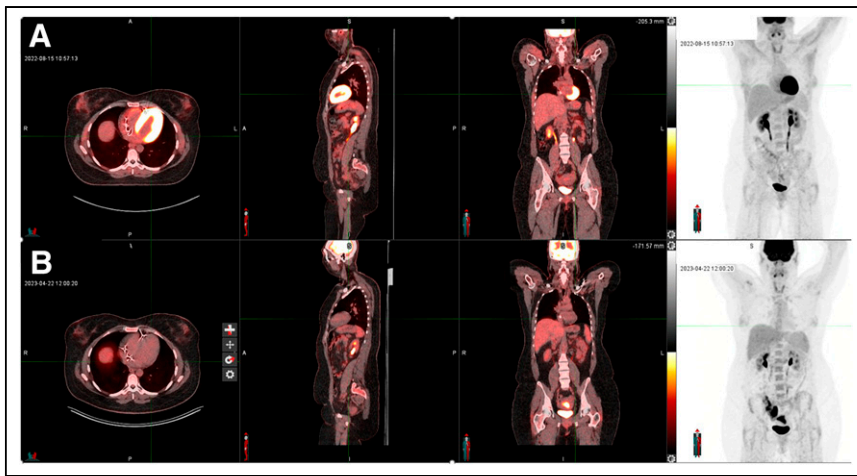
^{18}F -FDG PET/CT images in transaxial, sagittal, and coronal planes and maximum-intensity projection images. (A) Intense ^{18}F -FDG uptake in LV myocardium due to inadequate preparation. (B) No uptake in myocardium in same patient after appropriate preparation.
